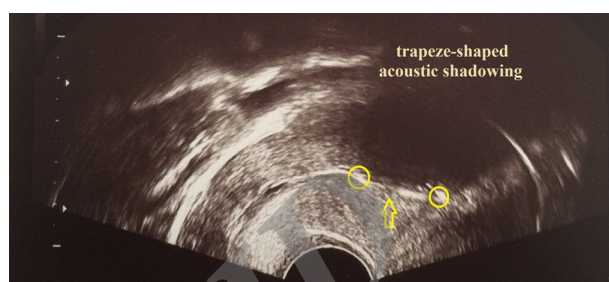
Sonographic Image of Mirena IUD on 2-D Transvaginal Ultrasound. The yellow circles are showing the ends of Mirena and the arrow is showing hormone cylinder.
